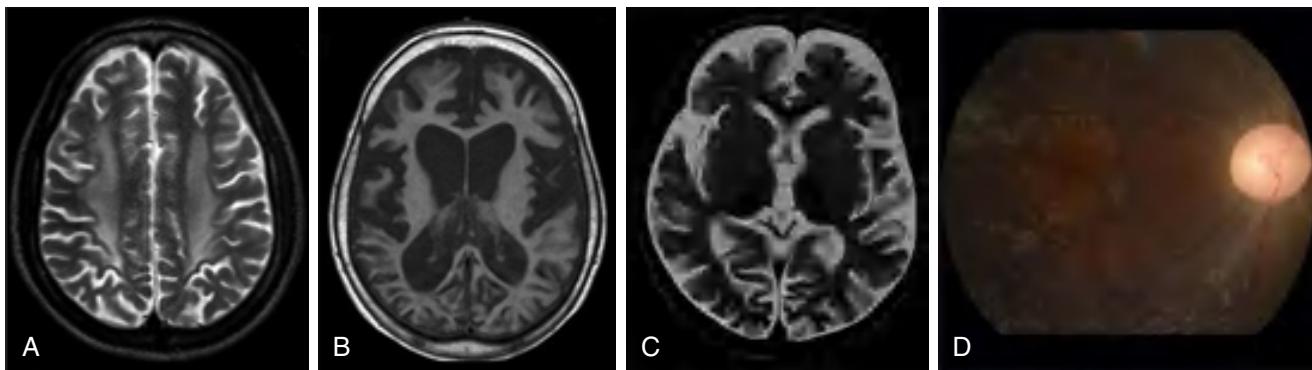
A, T2-weighted (axial) image showing leukoencephalopathy in a child with late infantile neuronal ceroid lipofuscinosis (NCL). B, T1-weighted (axial) sequence revealing diffuse atrophy in a child with late infantile NCL. C, A child with late infantile NCL with cerebellar atrophy in T2-weighted axial section of the brain. D, Fundus photograph showing atypical retinitis pigmentosa with optic atrophy in a child with juvenile NCL. (Modified from Jadav RH, Sinha S, Yasha TC, et al. Clinical, electrophysiological, imaging, and ultrastructural description in 68 patients with neuronal ceroid lipofuscinosis and its subtypes. *Pediatr Neurol*. 2014;50:85–95, Fig. 1, p. 88.)
